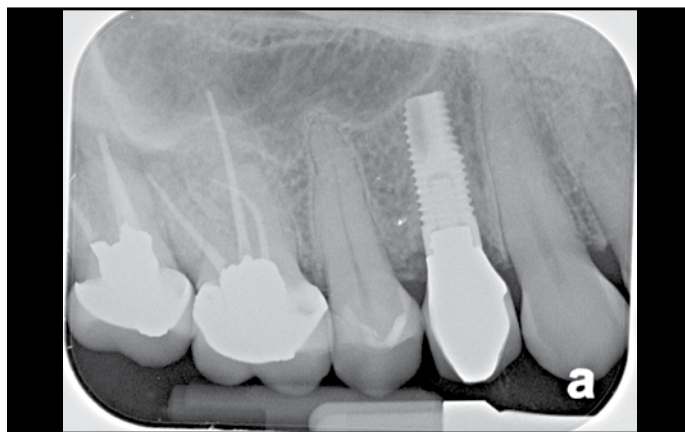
Periapical radiograph of the seated final crown suggests good bone stability.
